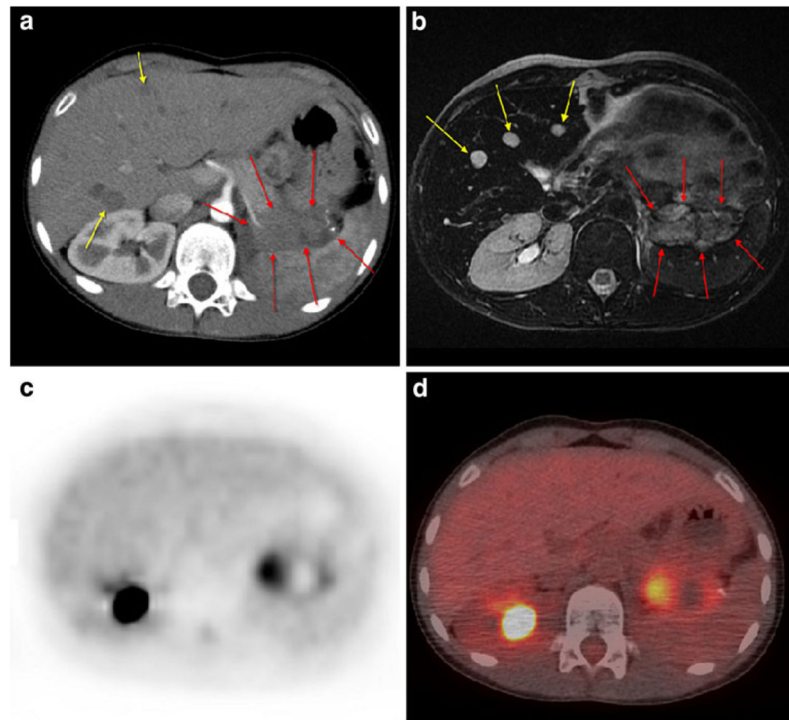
Patient 7: 10-year-old girl with left-sided recurrent Wilms' tumor showing two liver metastases (*yellow arrows*) on contrast-enhanced CT (a) and three foci on MRI (b) not detectable on PET scan (c) or on PET/CT fusion image (d without intravenous contrast). The lesion in the pancreatic tail area (*red arrows* on a and b) is evident in all images
